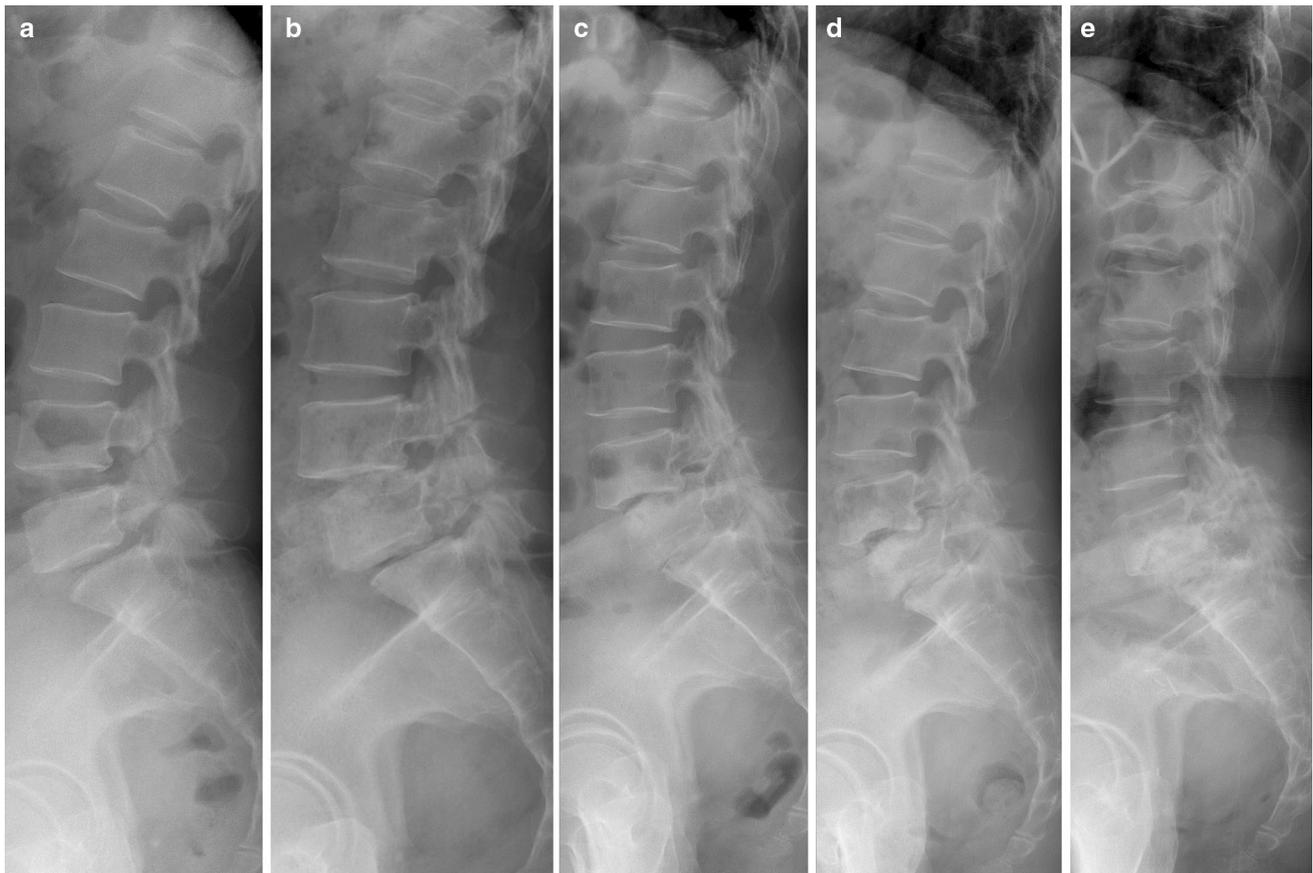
Serial lateral lumbar radiographs show progressive endplate destruction and collapse of the intervertebral disc space. a Double-level isthmic spondylolisthesis at L4–5 and L5–S1 at initial visit
